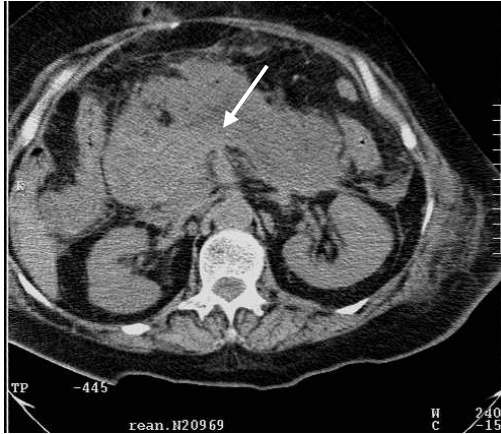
CT. The pancreas enlarged with ill-define borders (arrow). Acute pancreatitis
